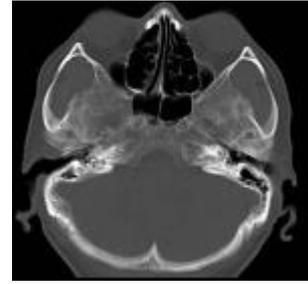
CT examination results.
